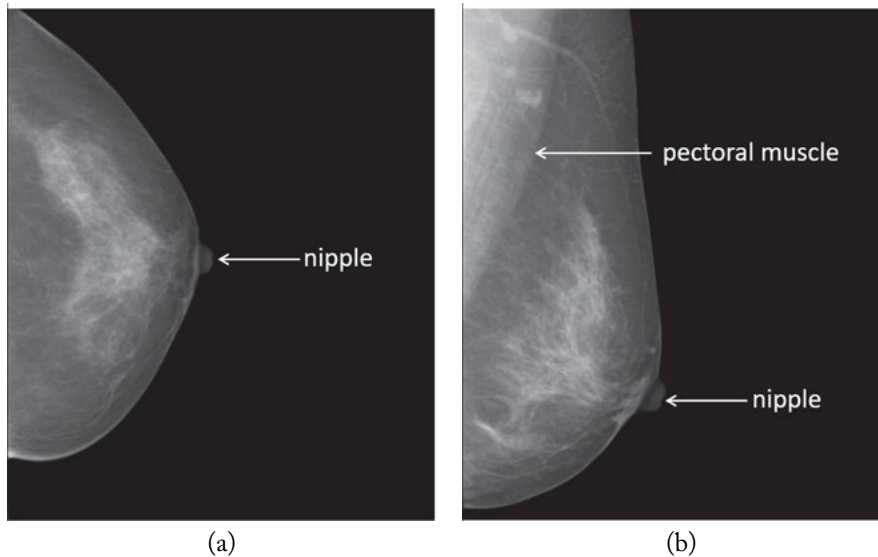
(a) The craniocaudal (CC) view and (b) the mediolateral-oblique (MLO) view of the right breast of a patient. The mammograms show normal breast parenchyma with normal radiographic density. The FFDM images were acquired at the San Paolo Hospital of Bari, Italy (see Section 2.1.1 for more details).
